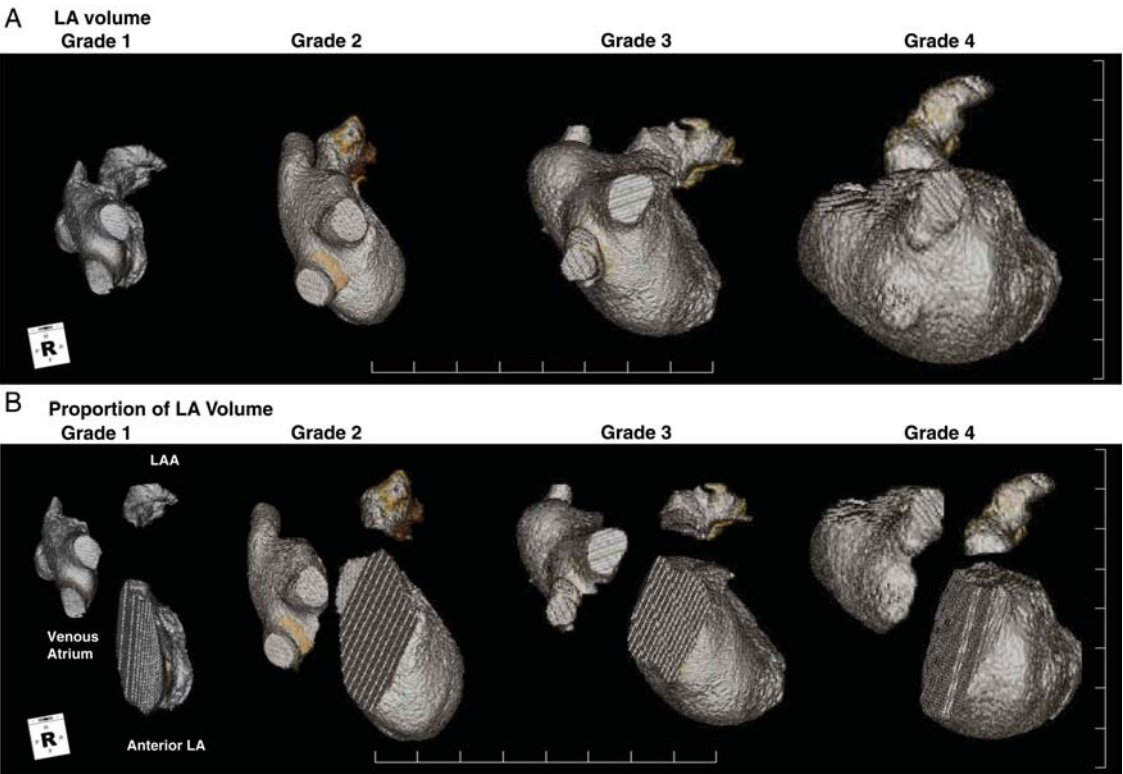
(A) Right lateral views of left atrium in the reconstructed three-dimensional spiral computed tomography image depending on the degree of left atrial remodelling. (B) left atrium images were divided into the venous atrium, the anterior left atrium, and the left atrial appendage. Volumetric measurement reveals significantly higher relative volume of the anterior left atrium in Stage 2 remodelling than in Stage 1.
